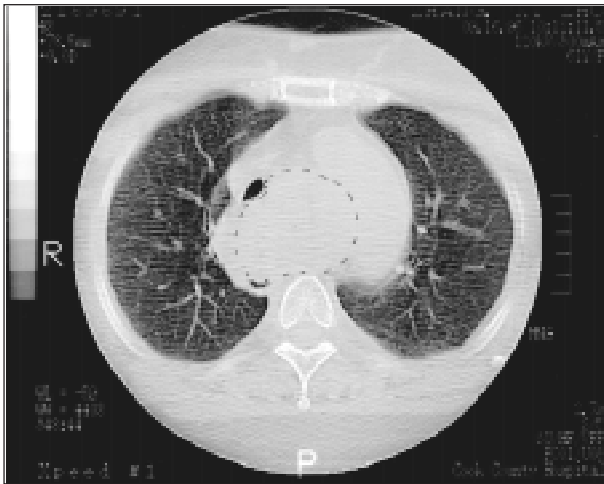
CT Scan of the patient from Fig. 3.1 demonstrating the posterior mediastinal mass which is posterior to the arch of aorta and has displaced the trachea anterolaterally.
